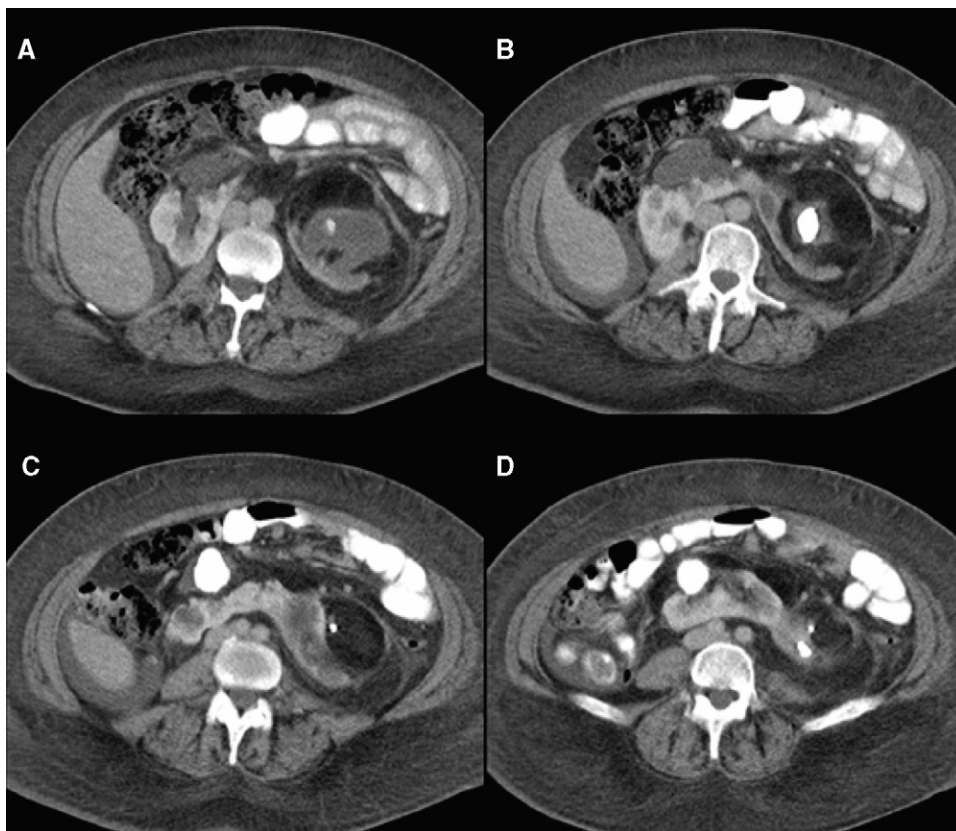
Sequential transverse computed tomography (CT) scans (A–D) of the abdomen showing the large stones in the left renal pelvis. Note ascites around the lower right lobe of the liver.
